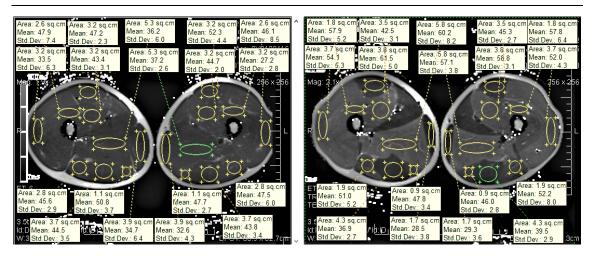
Representative regional changes in transverse relaxation time (T2) (at \approx 50% the length of the femur) as assessed by consecutive MRI scans before and 3-5 min after finishing an acute bout of the exercise (10 sets of 10 flywheel squats) from one of the volunteers. Lighter areas represent a higher T2 mean value, whereas darker areas represent lower T2 mean value.
